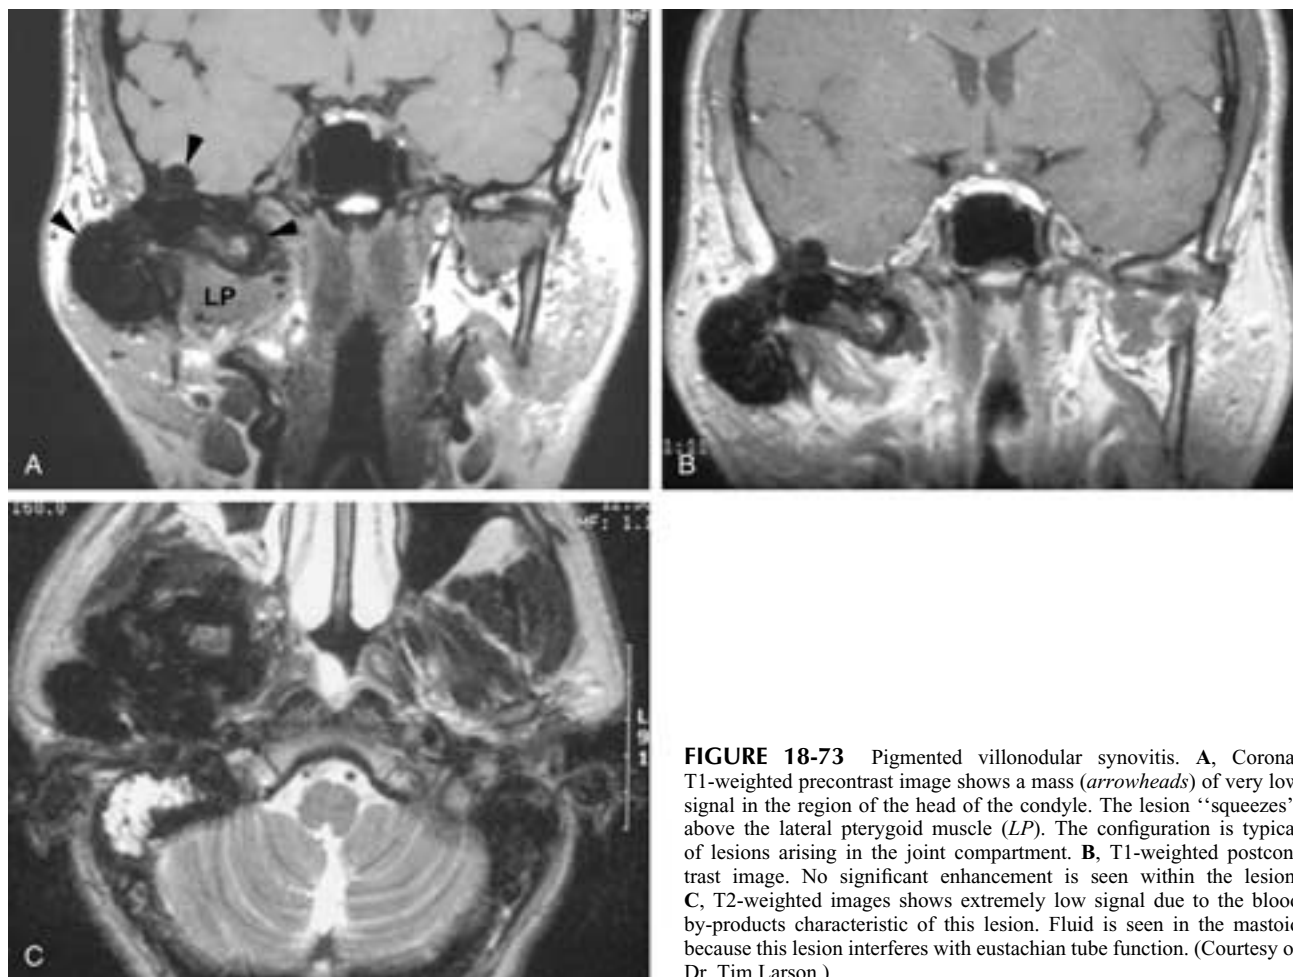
Pigmented villonodular synovitis. A, Coronal T1-weighted precontrast image shows a mass (arrowheads) of very low signal in the region of the head of the condyle. The lesion “squeezes” above the lateral pterygoid muscle (LP). The configuration is typical of lesions arising in the joint compartment. B, T1-weighted postcontrast image. No significant enhancement is seen within the lesion. C, T2-weighted images shows extremely low signal due to the blood by-products characteristic of this lesion. Fluid is seen in the mastoid because this lesion interferes with eustachian tube function. (Courtesy of Dr. Tim Larson.)
